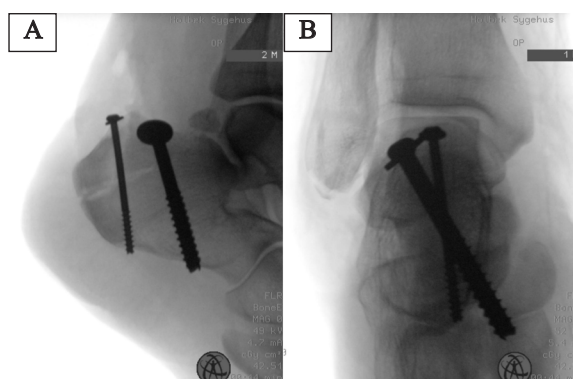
Intraoperative radiographs during initial fixation, showing (A) lateral view of the calcaneus and (B) anteroposterior view of the ankle, with good fracture alignment and appropriate positioning of cannulated screws.
